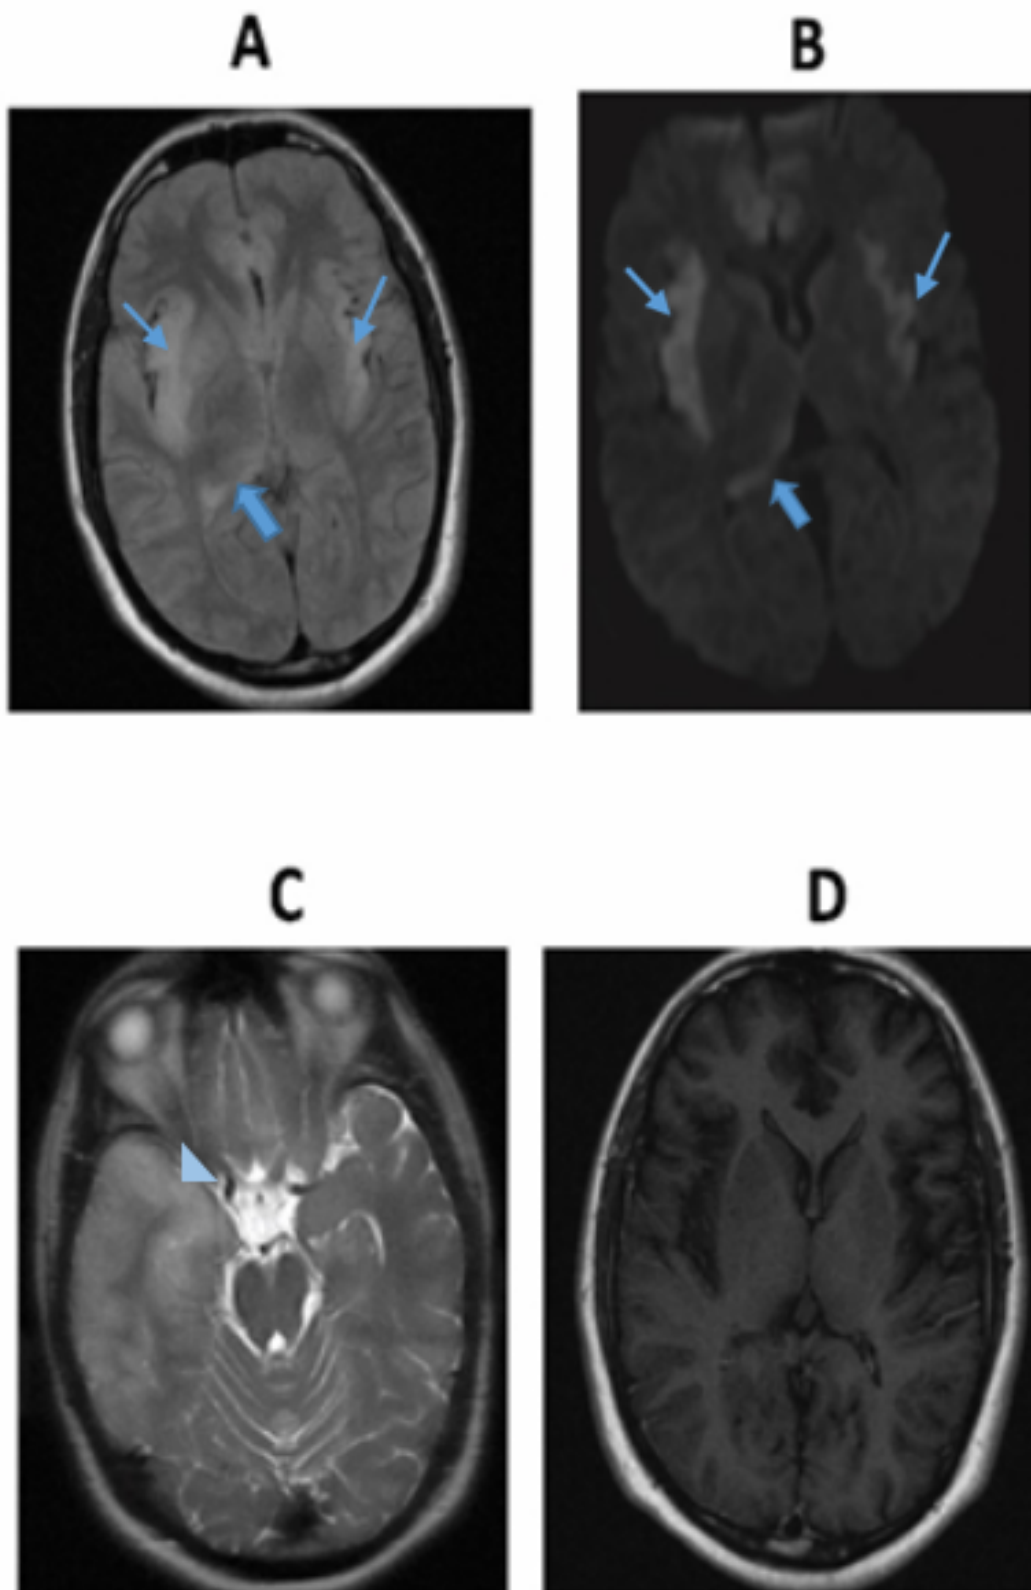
A) Inversion recovery magnetic resonance imaging (FLAIR MRI) showed hypersignal lesions in both insula (thin arrows) and the right thalamus (thick arrow); B) Diffusion-weighted MRI (DWI) showed restriction; C) T2 weighted image: hypersignal lesion in right temporal lobe (arrowhead); D) T1-weighted MRI with contrast: no gadolinium enhancement
